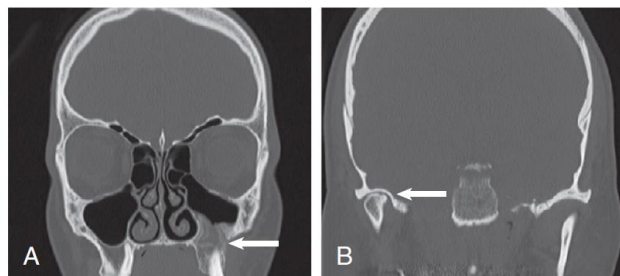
Incidental computed tomography findings of patients seen initially with nonsinogenic facial pain. A, Left odontogenic cyst (arrow). B, Degenerative changes of the right temporomandibular joint (arrow).
